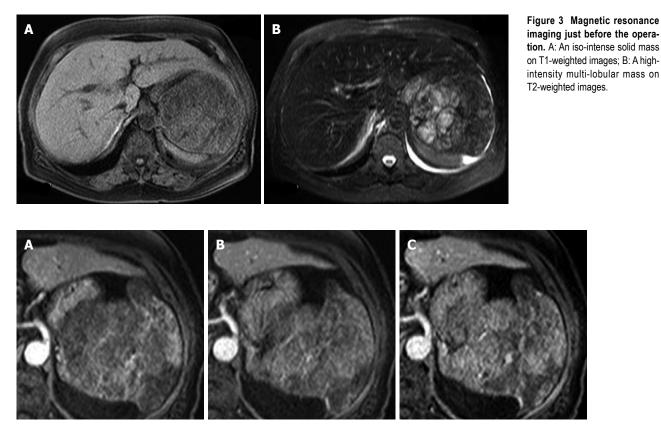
Dynamic magnetic resonance imaging. The tumor was enhanced from 20 to 120 s after the injection of contrast medium. Contrast medium gradually pooled in the tumor. A: 20 s; B: 60 s; C: 120 s.
